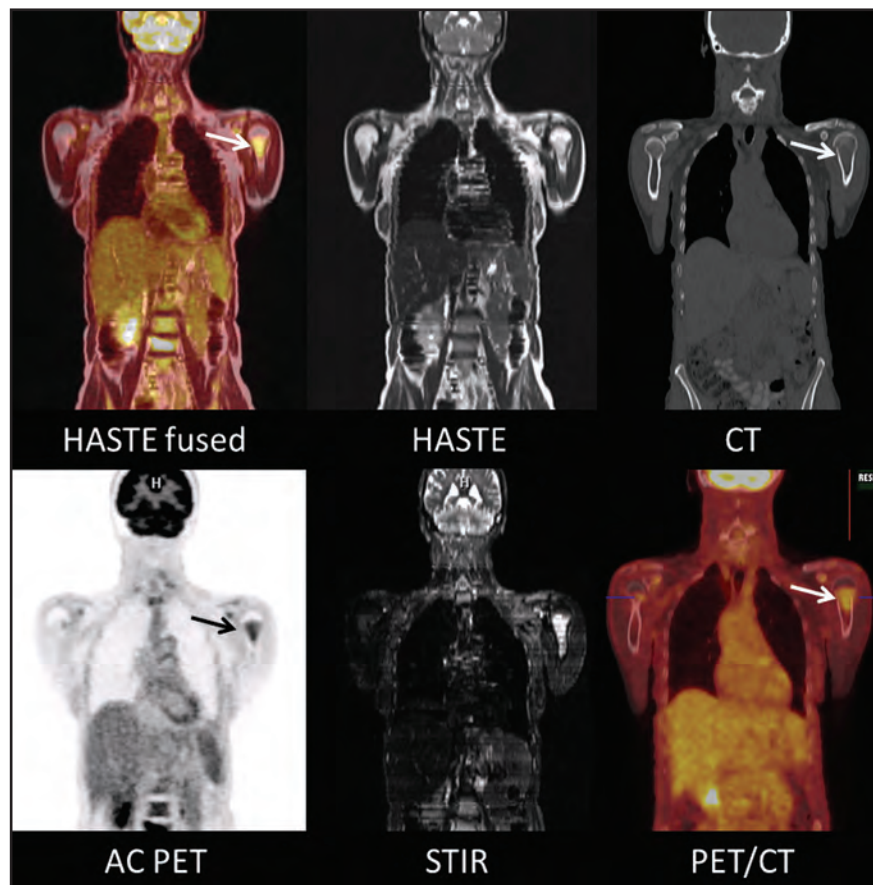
Multiple myeloma. Images depict a focus of metabolically active disease in the left humeral neck that is more conspicuous on MRI than on CT alone (arrows).
